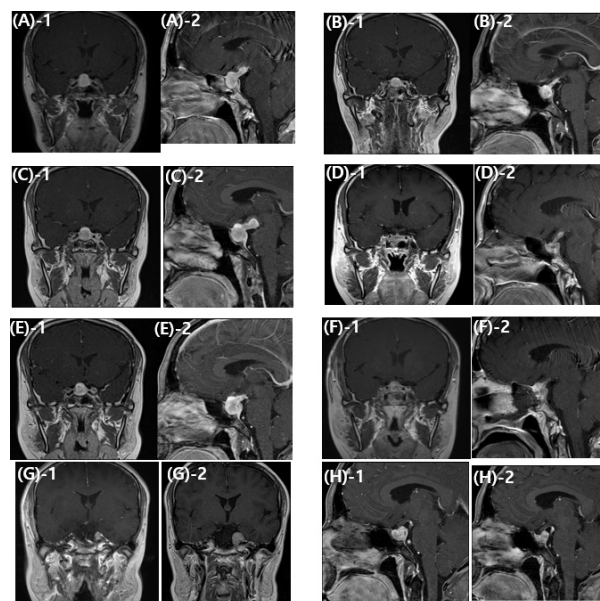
Changes on MRI after treatment with pharmacological doses of glucocorticoids or surgery for primary lymphocytic hypophysitis. Image (A) and image (B) showed the change in lesion size ; preglucocorticoids compared to postglucocorticoids treatments in a patient at 1st diagnosed. Image (C) and image (D) showed the change in lesion size ; preglucocorticoids compared to postglucocorticoids treatments in a patient at 1st recur. . Image (E) and image (F) showed the change in lesion size ; preglucocorticoids with azathioprine compared to postglucocorticoids treatments in a patient at 2nd recurrence. . Image (G) and image (H) showed the change in lesion size ; preglucocorticoids with azathioprine compared to postglucocorticoids treatments in a patient at 3rd recurrence.
